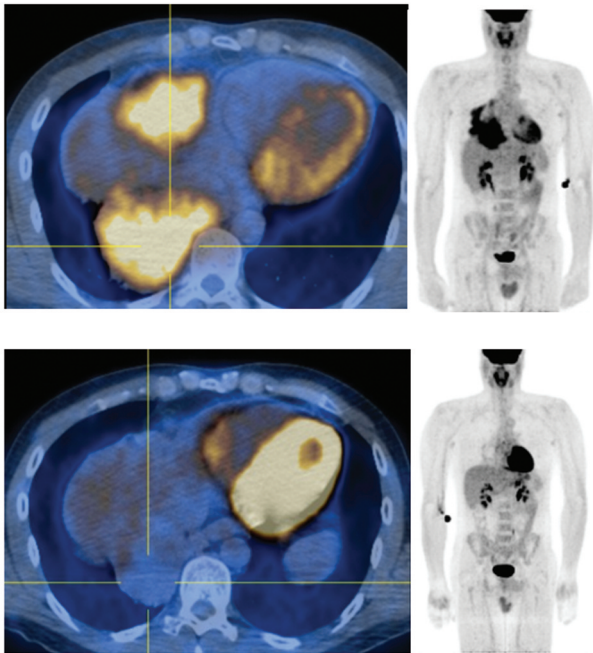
Positron emission tomography-computed tomography (PET/CT) scan. Top: Before induction chemoradiation. Bottom: After induction chemoradiation.
